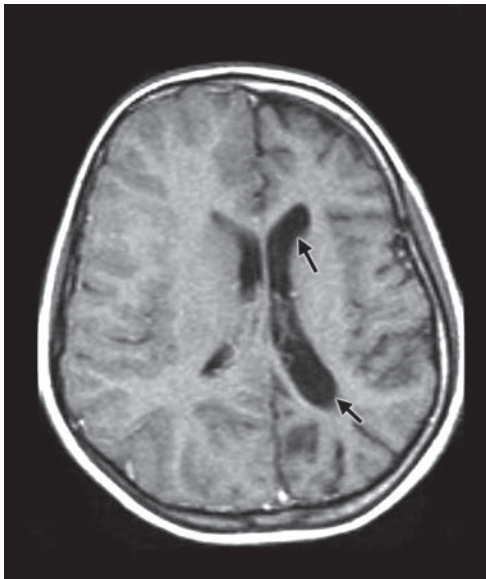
Axial T1W MRI image of brain showing atrophy of the cerebral hemisphere with prominent ventricles (arrows) in hemiplegic cerebral palsy
